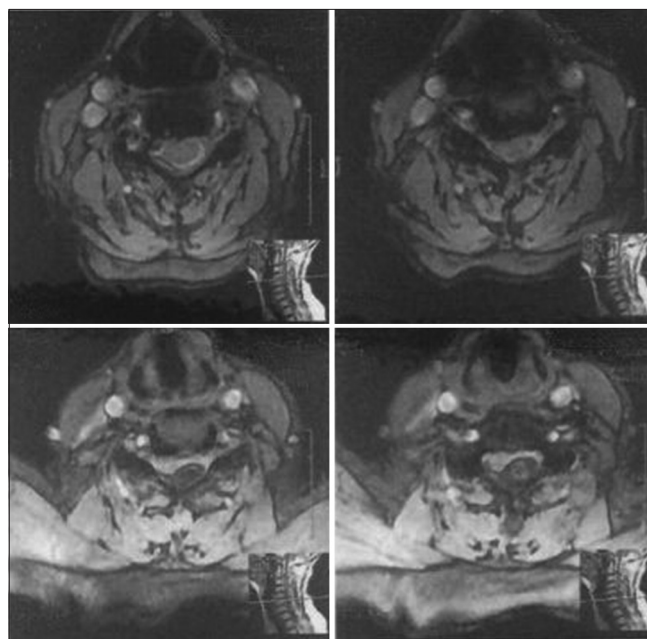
T2-weighted axial magnetic resonance images showing a mixed intensity acute hematoma compressing the spinal cord in epidural space at the C3-T1 levels
